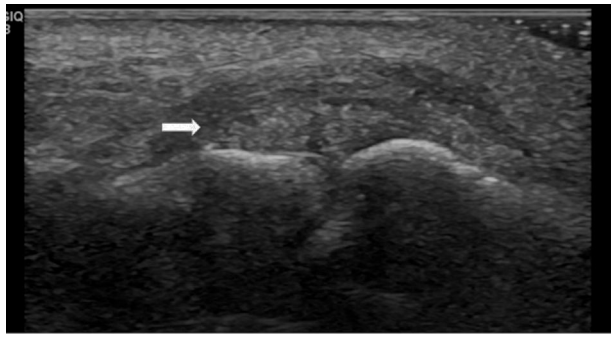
Ultrasound longitudinal view demonstrating an ovoid heterogeneous mass with hyperechoic foci adjacent to proximal interphalangeal joint (arrow).
